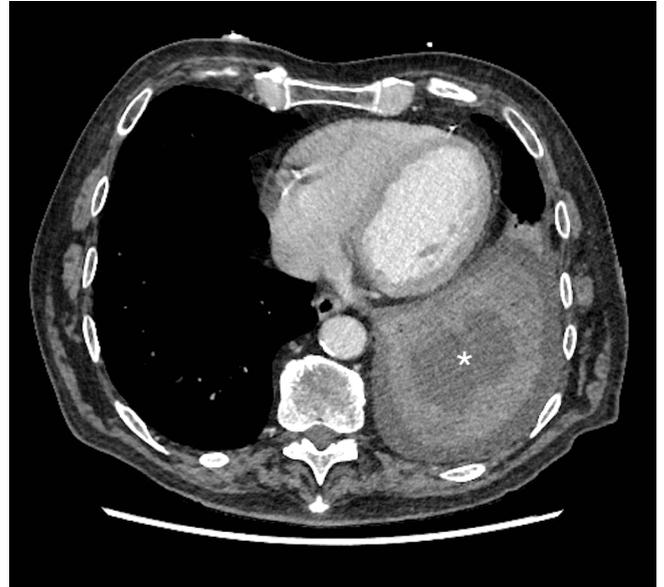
Axial view of computed tomography of the lung demonstrating the lung abscess (asterisk) within consolidated lung.
